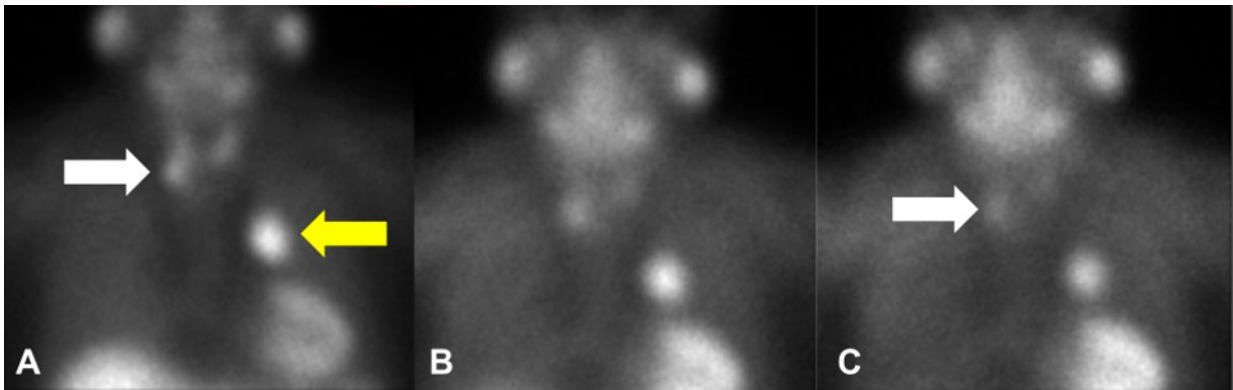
Dual-phase parathyroid scintigraphy showed a sestamibi-avid focus in the inferior third of the right thyroid lobe (white arrow) in the early phase of imaging 15 minutes post-sestamibi administration (A), which decreased in intensity on the delayed 4-hour image (C). A persistently sestamibi-avid focus is also seen in the mediastinum throughout the study (yellow arrow).
